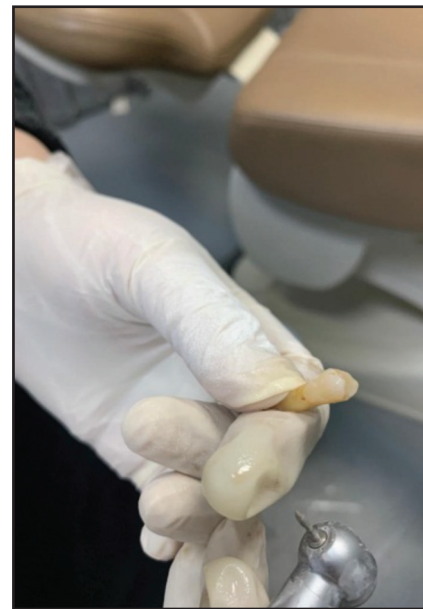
Cleaning teeth ultrasonically
